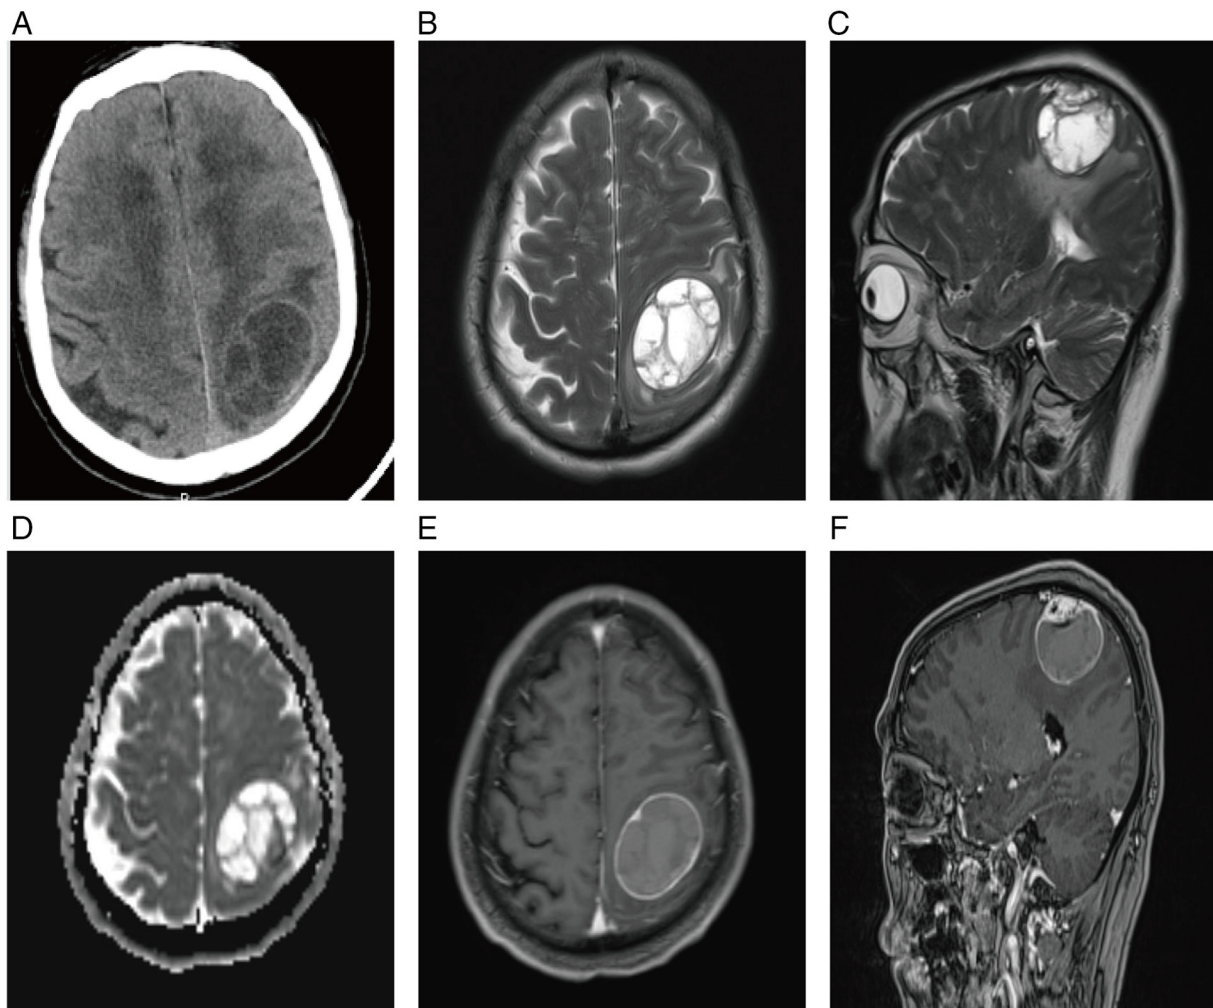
Patient imaging data. (A) Computed tomography plain scan shows a mixed low-density circular mass in the left parietal region. (B) MRI T2WI axial image shows a mass at the left parietal region, presenting a mixed signal of cystic and solid masses. (C) MRI T2WI sagittal image shows that the solid part of the tumor is connected to the meninges. There is an arachnoid space between the tumor and the brain tissue, and there is slight edema in the peritumoral brain tissue. (D) High signal on apparent diffusion coefficient. (E) Enhanced MRI axial image shows that the cystic part of the tumor is not notably enhanced. (F) Enhanced MRI sagittal image shows that the solid part of the tumor is markedly enhanced. MRI, magnetic resonance imaging; WI, weighted imaging.
